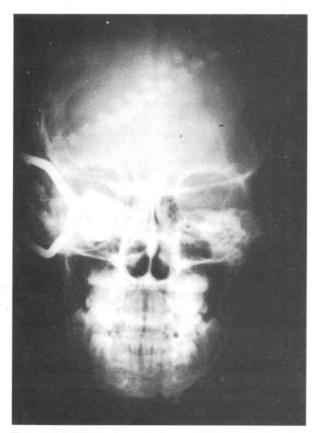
(a) Posterior-anterior and (b) lateral x-ray films of the skull show the penetrating spear.
